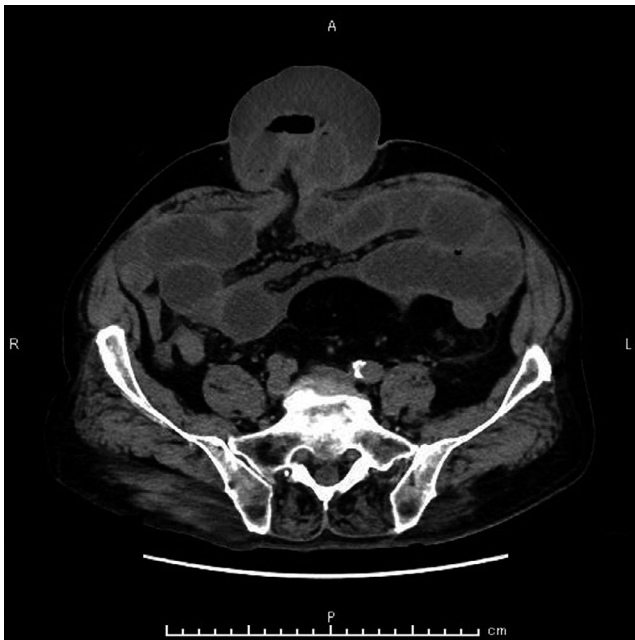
Plain computed tomography of the abdomen revealed incarceration of the small intestine
